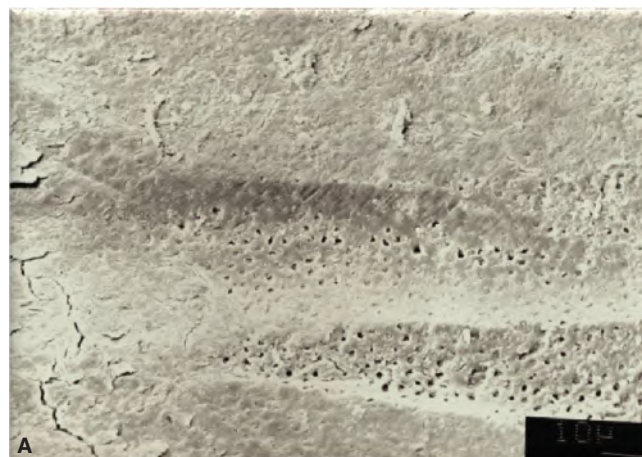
A. Longitudinal grooves in the root dentin following the use of ultrasonically activated files. B. Root canal wall following use of ultrasonics. Smear layer and debris have been removed completely.
